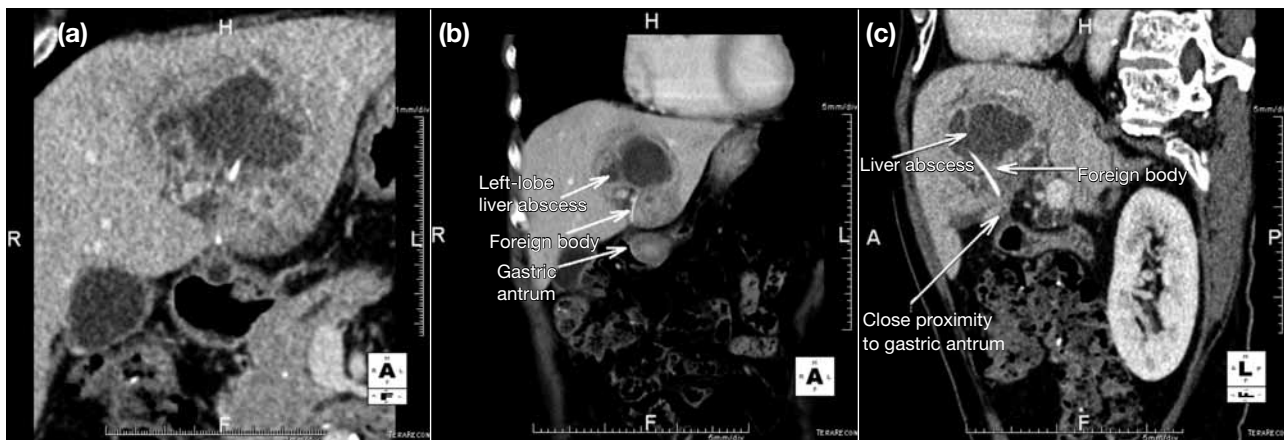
(a) Reconstructed computed tomography (CT) confirms the ultrasound-detected lesion to be an abscess collection. (b and c) Curvilinear hyperdense foreign body is noted. The use of multiplanar reformatting of CT enables demonstration of the foreign body, and its relationship with other anatomical structures. In this case, it is noted to be in close proximity with the gastric antrum.
